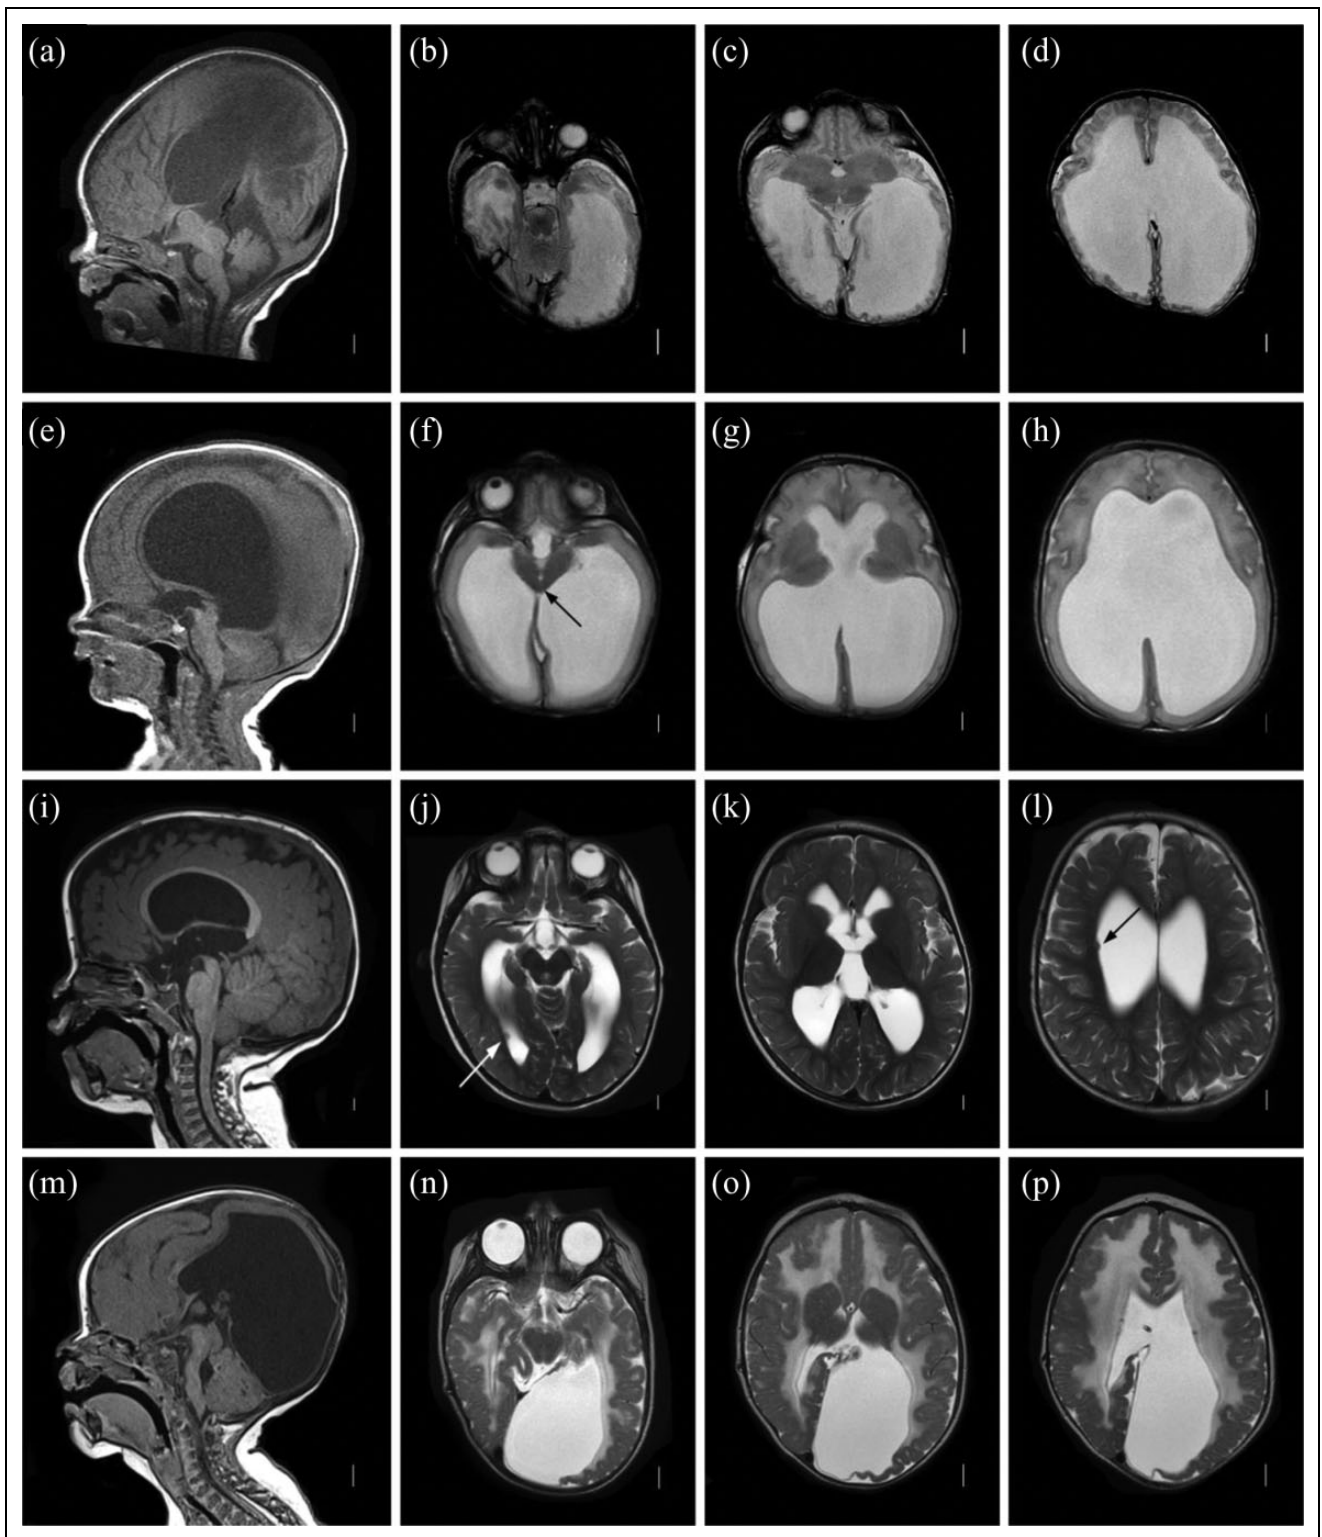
Aqueductal obstruction. (A-D) Aqueductal obstruction associated with *LICAM* mutation. Sagittal T1 MRI image (A) showing complete aqueductal occlusion (arrow) and small cerebellum. Axial T2 images (B-D) demonstrating extensive dilation of lateral ventricles. (E-H) Mesencephalosynapsis. Sagittal T1 images (A) demonstrating inferior aqueductal occlusion with funneled aqueduct (arrow). Axial T2 images (F-H) showing fused inferior colliculi (arrow) and severe ventricular dilation. (I-L) Periventricular nodular heterotopia with aqueductal nodule. Sagittal T1 image (A) showing obstructive nodule within aqueduct (arrow). Axial T2 images (J-L) demonstrating moderate ventricular dilation and periventricular nodular heterotopia (arrows). (M-P) Muscle-eye-brain disease. Sagittal T1 image (M) showing enlarged tectum with complete aqueductal obstruction (arrow), hypoplastic and kinked brainstem, and cerebellar dysplasia with cysts. Axial T2 images (N-P) showing cobblestone cortex and abnormal white matter.
